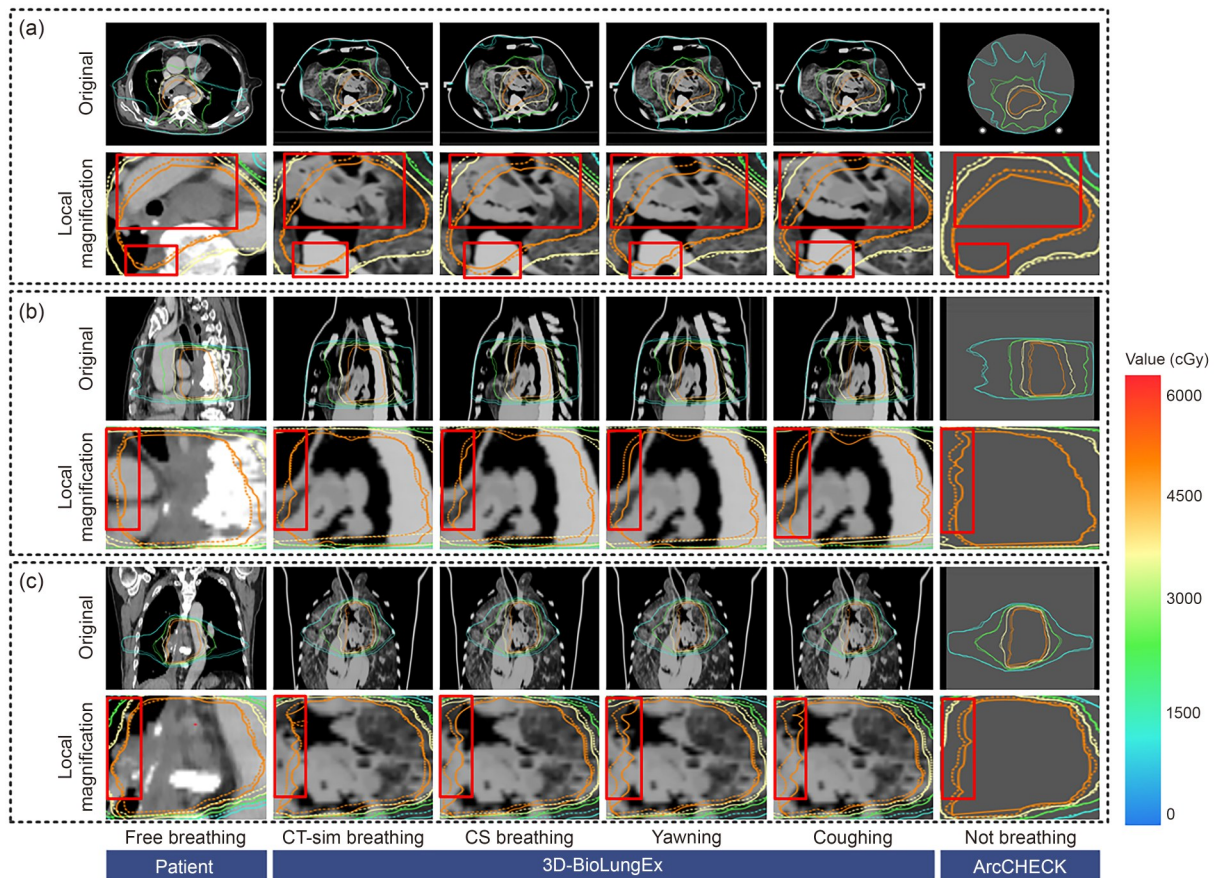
Qualitative comparison of biological in vivo 3D dose distribution. (a) Dose distributions in the axial CT (the first row, original CT images; the second row, magnified views of high-dose regions, with red boxes highlighting areas exhibiting significant differences between planned and measured dose distributions). (b) Dose distributions in the coronal CT (the first row, original CT images; the second row, magnified views of high-dose regions, with red boxes highlighting areas exhibiting significant differences between planned and measured dose distributions). (c) Dose distributions in the sagittal CT (the first row, original CT images; the second row, magnified views of high-dose regions, with red boxes highlighting areas exhibiting significant differences between planned and measured dose distributions)
